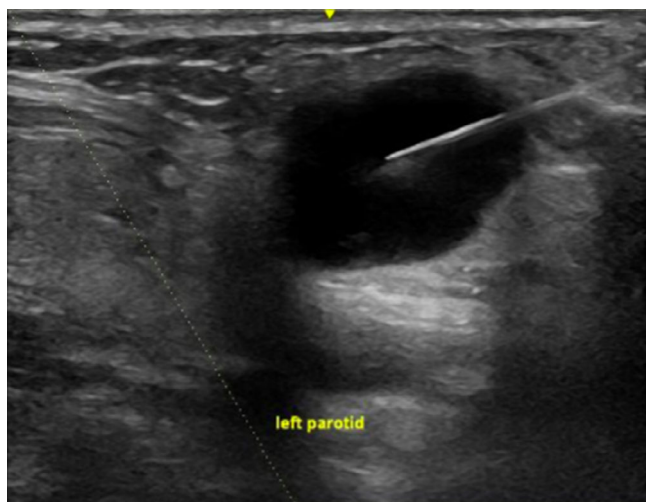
Benign-appearing parotid lesion on ultrasonography, ultimately determined to be a pleomorphic adenoma. Note the smooth, well-demarcated borders, and homogeneous hypoechogenicity
